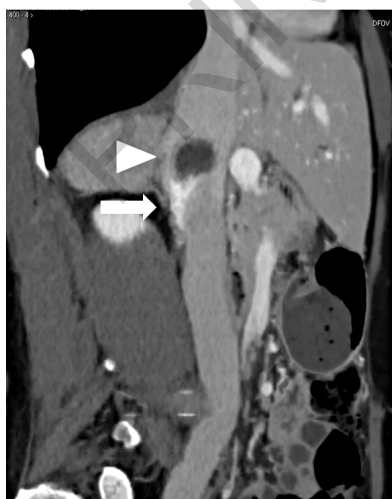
Epithelioid haemangioendothelioma. Para-sagittal multiplanar reconstruction of venous phase of contrast enhanced CT shows an intraluminal non-enhancing mass (arrowhead) with peduncolated hypervascular structure (arrow) attached to the wall of the inferior vena cava.
